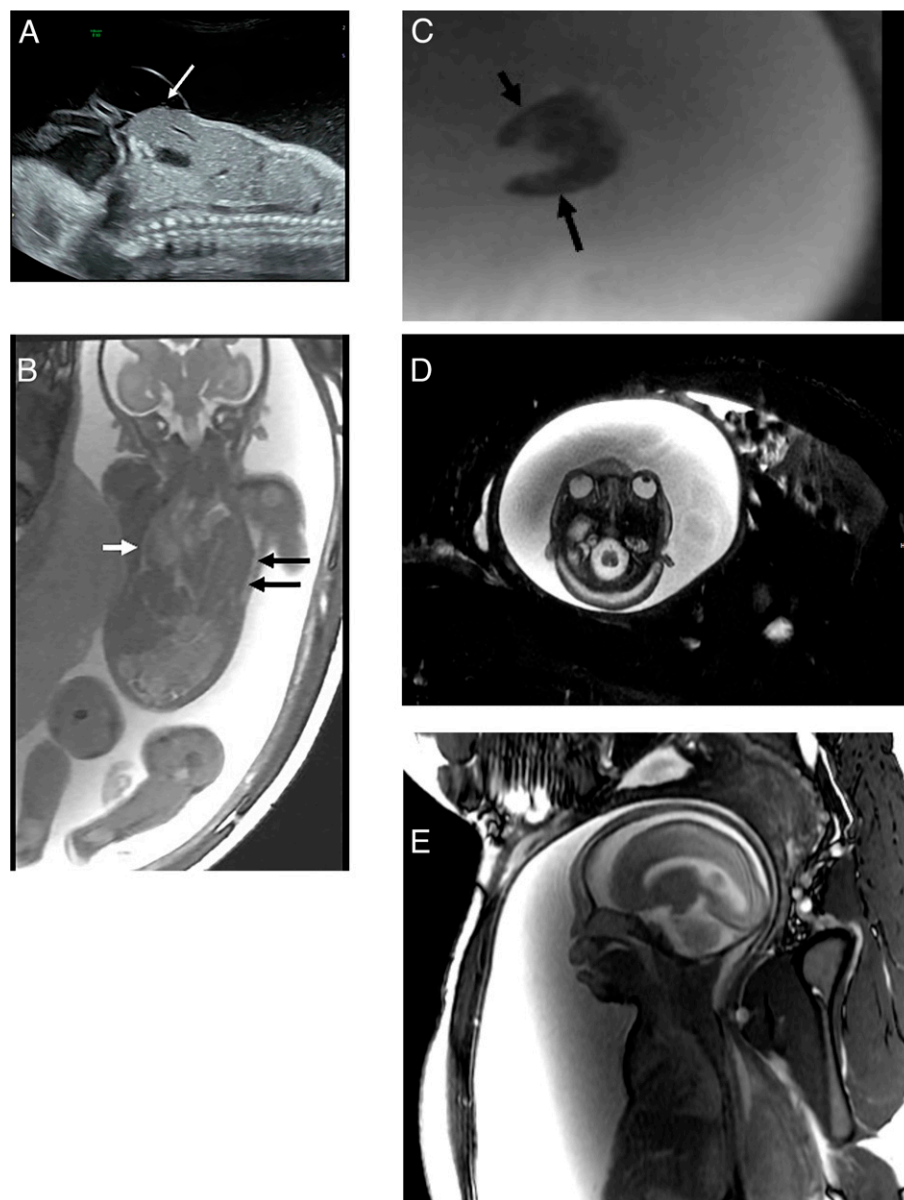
A. Fetal ultrasonography at 26 3/7 weeks' gestation showing a small abdominal omphalocele (arrow). Fetal magnetic resonance imaging scan at 26 3/7 weeks' gestation showing congenital diaphragmatic hernia with liver (black arrows) herniated into left chest and heart displaced into right chest (white arrow) (B); deformed hand (arrows) (C); widely spaced eye globes (D); coarse facial features and prominence of extra-axial spaces (E).
